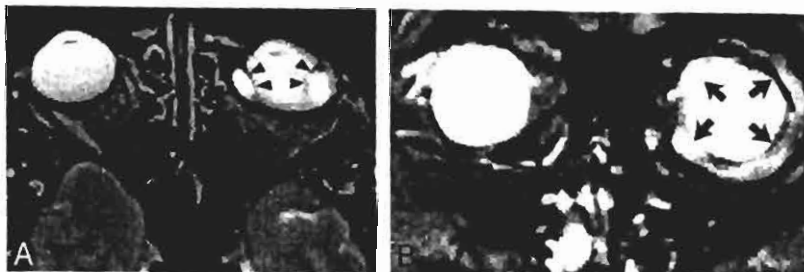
A and B, T2-weighted axial (A, case 2) and coronal (B, case 4) MR images (2000/80/1) show circumferential, hyperintense mass (arrowheads, arrows) surrounding the globe. Increased T2 signal reflects increased water content and swelling of hydrolyzed buckle material.
